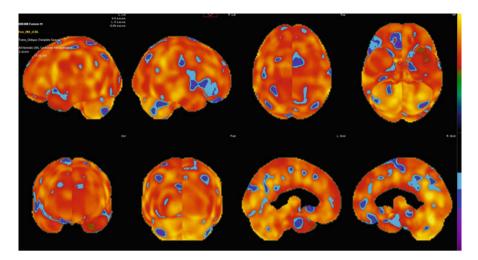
Surface-shaded display derived from SPECT scan. *Blue-lpurple*-shaded areas demonstrate perfusion well below the normal range. There is reduced relative uptake in a patchy fashion, but this is not indicative of any particular diagnosis. The images were acquired on a GE Discovery 670 gamma camera, and the surface-shaded display was generated on a MIMneuro workstation (Image provided by Nuclear Medicine, Western General Hospital, Edinburgh)
